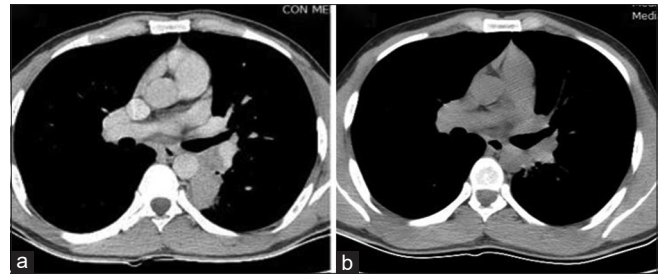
Comparison of computed tomography image before and after treatment: (a) initial computed tomography, same as Figure 2a, (b) follow-up image after 2 months of antitubercular treatment
